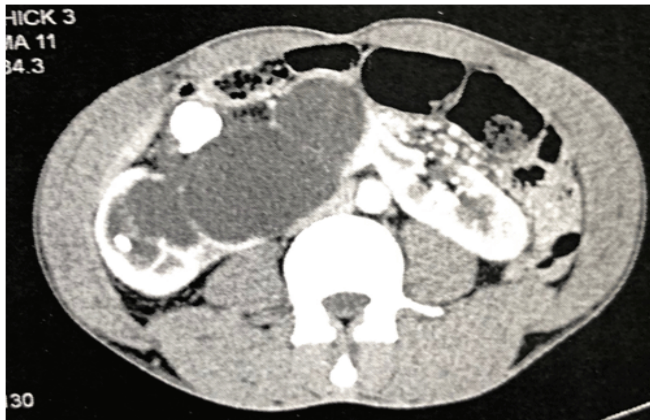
Transverse section of the uro-CT showing a horseshoe kidney with a huge dilation of the right kidney
